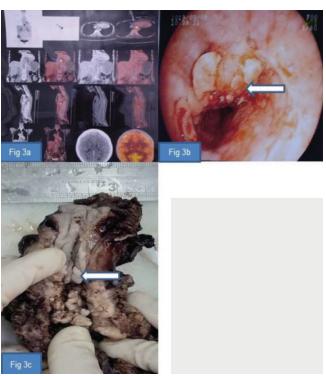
Fig 3a: PET-CT showing metabolically active asymmetric enhancing mural thickening at lower oesophagus. Fig 3b: Gastroesophageal endoscopy with an ulceroproliferative growth in the oesophagus. Fig 3c: Gross image revealing a greyish white ulceroinfiltrative growth in the distal oesophagus involving the GE junction.
